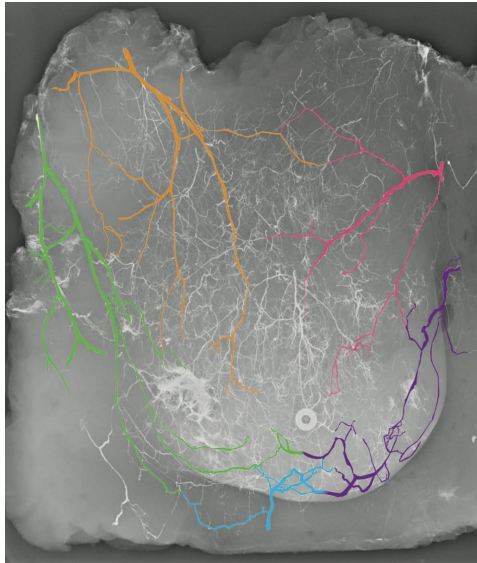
Resultant venogram of the right breast using plain radiography showing the venous drainage of the breast, including the inferolateral veins (green), superolateral veins (orange), medial veins (pink and purple), and inferior veins (blue). Note the anastomoses between the dominant veins around the nipple-areola complex. *From Le Roux C, et al. Preventing venous congestion of the nipple-areola complex: an anatomical guide to preserving essential venous drainage networks. Plast Reconstr Surg 2011;127(3):1073-1079.*
